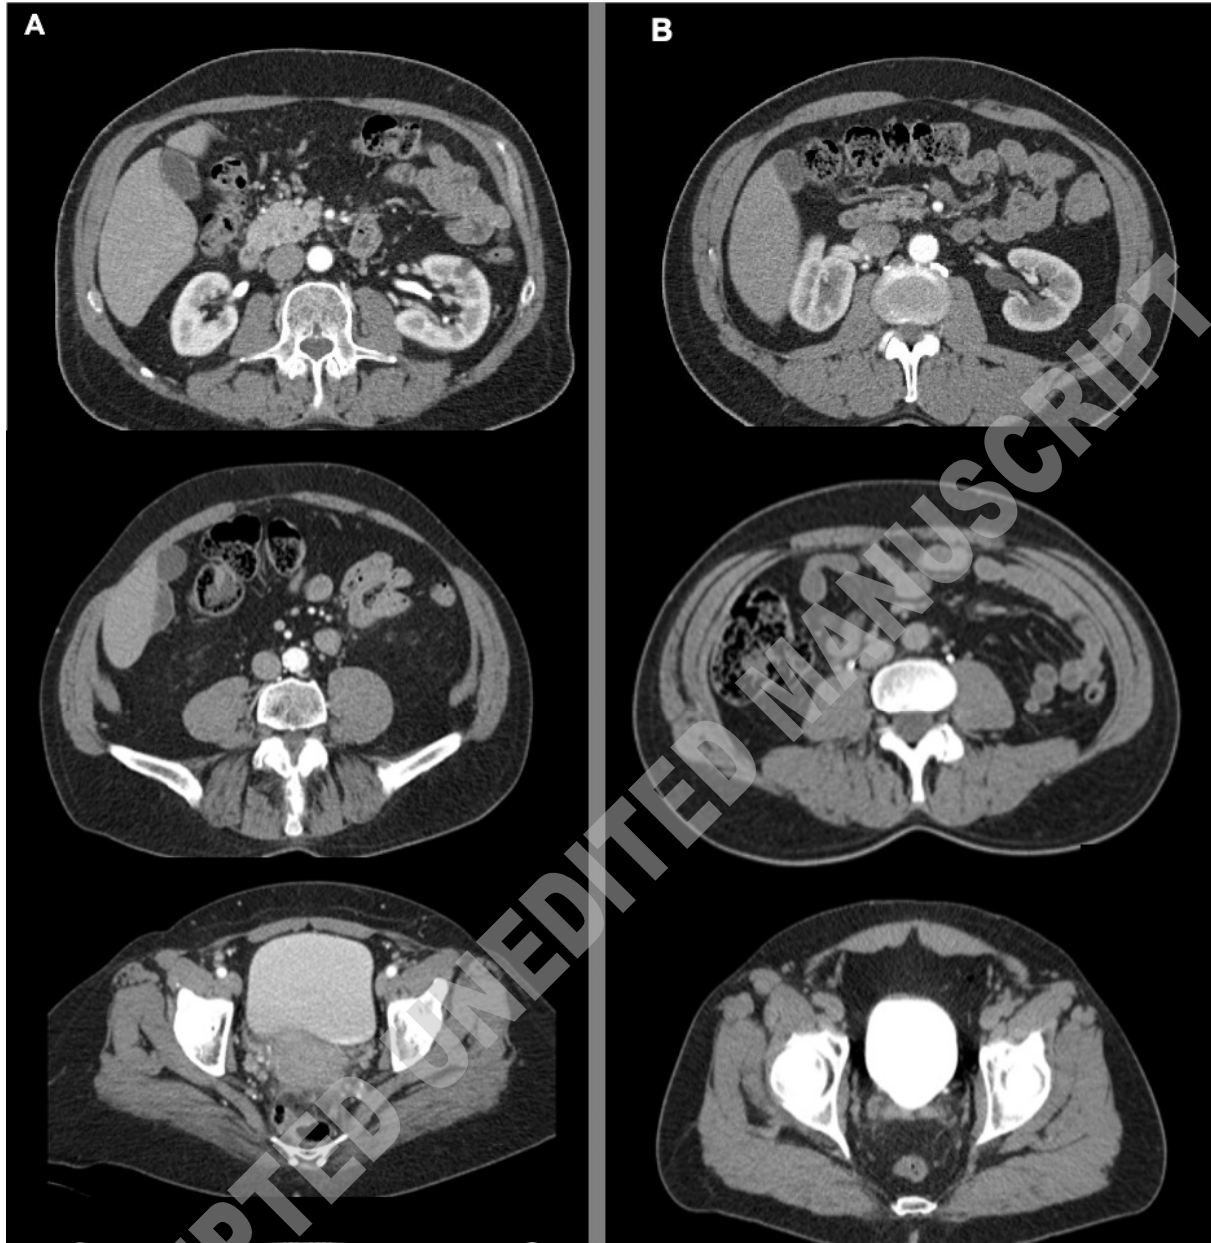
Sample images of CT urography from three separate scans using A) the triple bolus CT protocol (average scores of 42.3, 26.3, 40.3 in the top, middle, and bottom images) and B) the conventional CT protocol (average scores of 43.7, 44.7, 41.7 in the top, middle, and bottom images).
